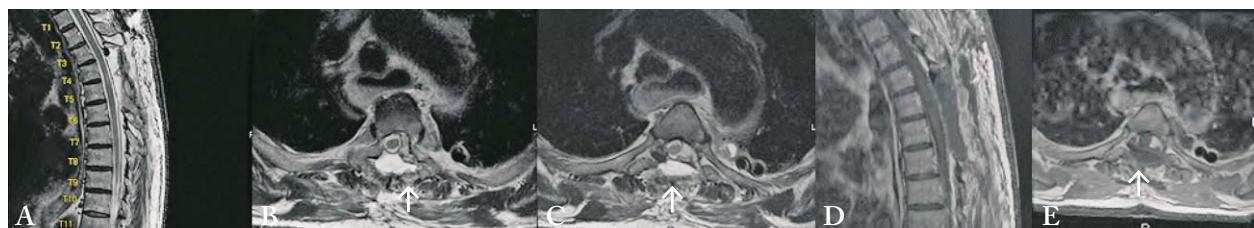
Postoperative MRI of the thoracic spine: (A) T2-weighted sagittal sequence showing complete resection of the tumor; (B, C) T2-weighted axial sequences; (D) post-contrast T1-weighted axial sequence showing no signs of contrast enhancement; (E) post-contrast T1-weighted axial sequence. Note the fat pad (arrow) applied dorsally to the dural suture.
